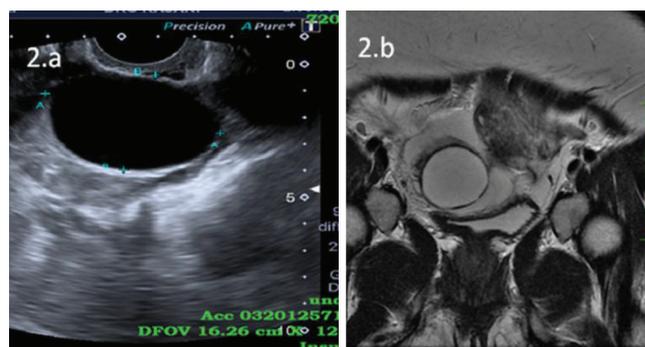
Ultrasound pelvis of a 32-year-old female shows a large para ovarian cyst (a). MRI pelvis of a 32-year-old female shows a large para ovarian cyst with hemorrhage seen within and around the cyst (b).
